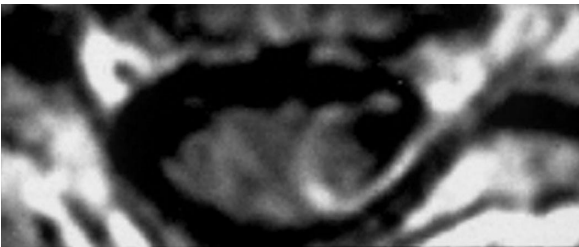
Magnetic resonance image of a patient with acute herpes zoster. Spinal cord in the cervical affected region. Note the contrast enhancement in the dorsal root, dorsal horn of the spinal cord and lesser also in the ventral root. The patient was severely affected with pain and motor weakness at the left arm (T1 image with contrast medium). Photo courtesy of Prof. Dr. T. Tölle, Munich.
